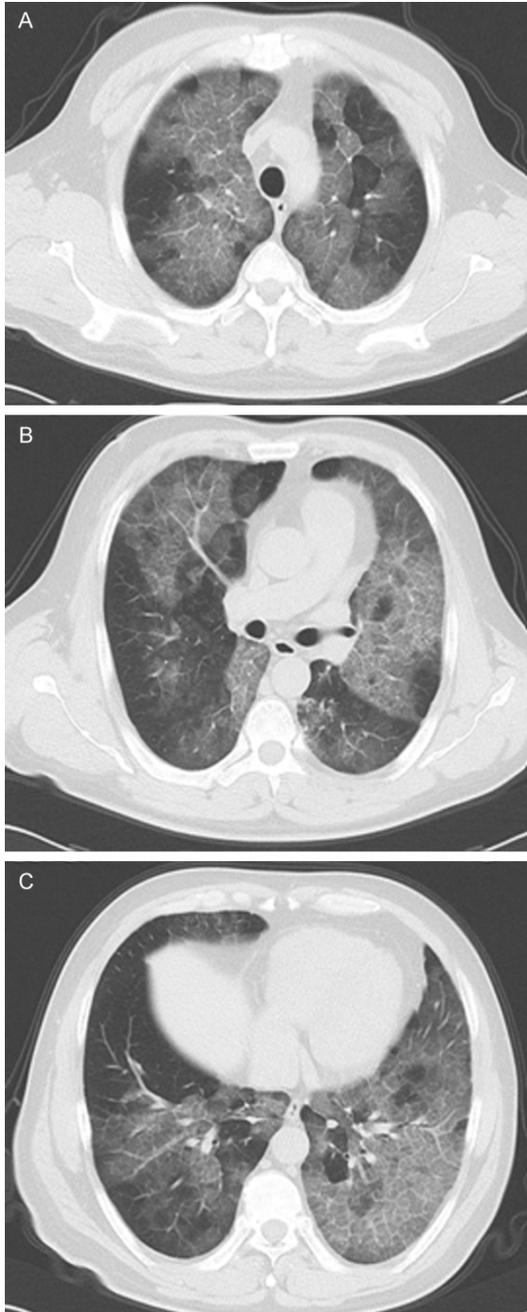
(A-C) High-resolution CT scan at the level of superior (A), middle (B), and inferior (C) pulmonary lobe. The presence of the reticular pattern superimposed on bilateral ground glass opacity (crazy-paving pattern).
